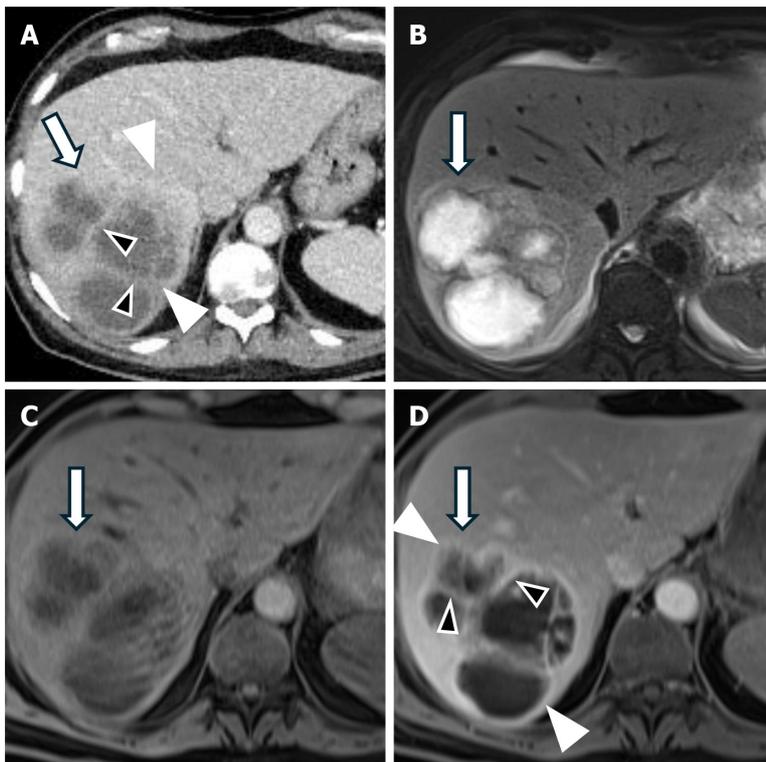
Mucinous cystic neoplasm of the liver. A: Axial contrast-enhanced computed tomography image shows a lobulated lesion (arrow) with an enhancing wall (white arrowheads) and septations (black arrowheads) in the right lobe of the liver; B: Axial T2 weighted MR image shows a T2 hyperintense lobulated lesion (arrow) with a thick wall and septations; C: Axial T1 weighted MR image shows a T1 hypointense lobulated lesion; D: Axial T1 weighted MR image with an extracellular gadolinium-based contrast agent in the portal venous phase shows a T1 hypointense lobulated lesion (arrow) with an enhancing thick wall (white arrowheads) and septations (black arrowheads).
